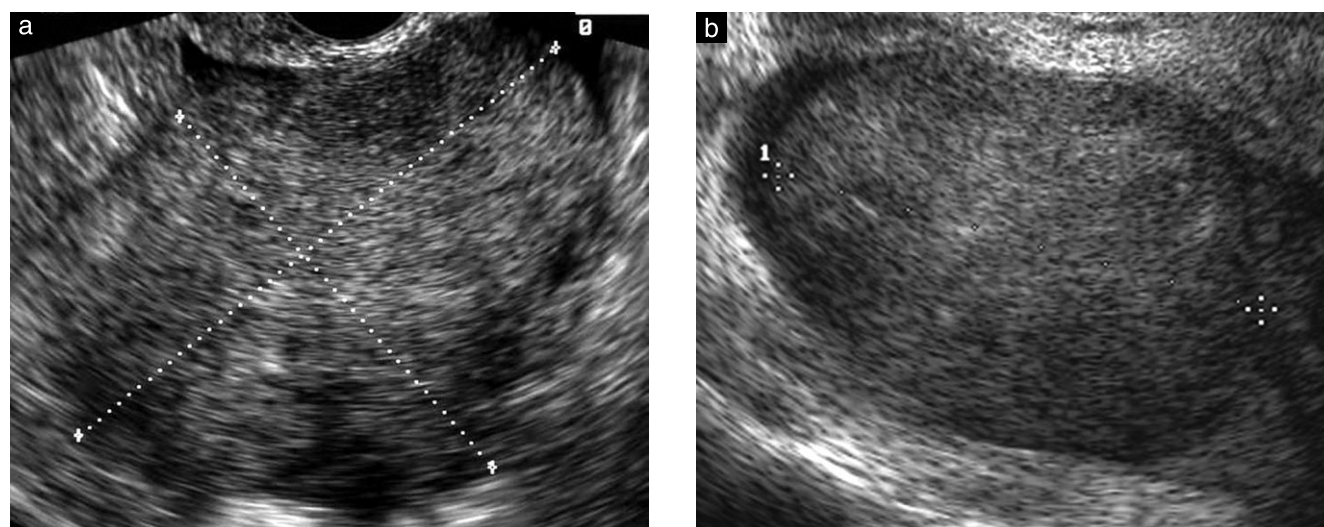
Ultrasound images of ovarian metastases derived from gastric tumors. Most are homogeneously solid lesions (a,b) with sharp borders. The border is well visualized if the metastasis is surrounded by fluid in the pelvis. These metastases move freely when pressure is exerted on them by the vaginal probe. Sometimes hypoechoic irregular areas within the solid mass change their homogeneously solid echostructure; this feature probably reflects necrosis (c,d,e).
